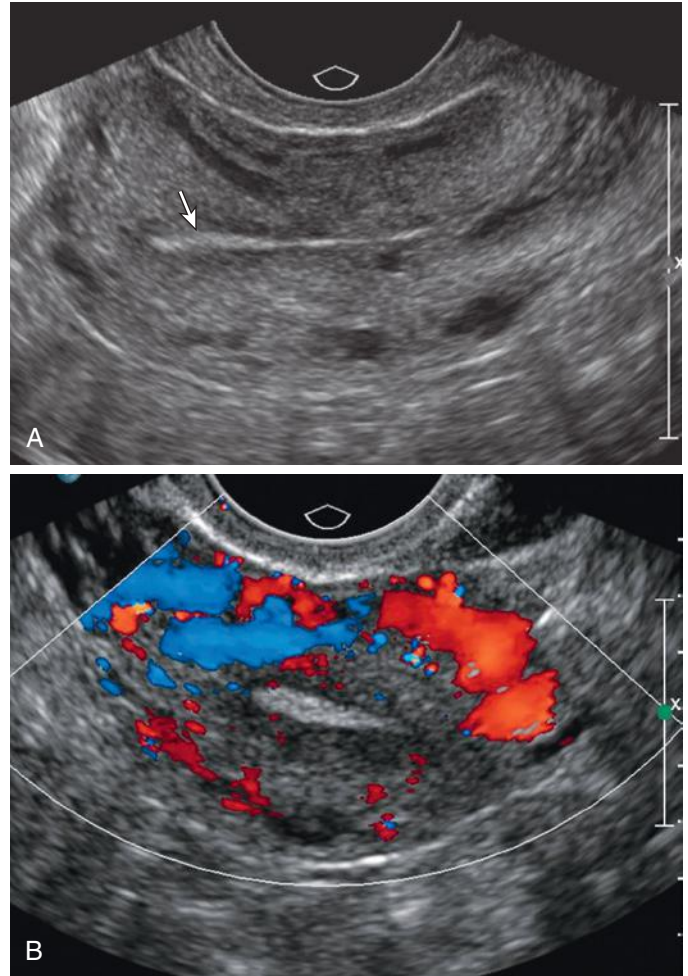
Arcuate venous plexus. A, Longitudinal gray-scale image of the uterus shows linear/tubular and circular anechoic regions representing the arcuate venous plexus in the uterine body separating the outer one third of the myometrium from the inner two thirds. Note the thin echogenic, early proliferative appearance of the endometrium (*arrow*). B, Transverse color Doppler image shows flow within these veins.
